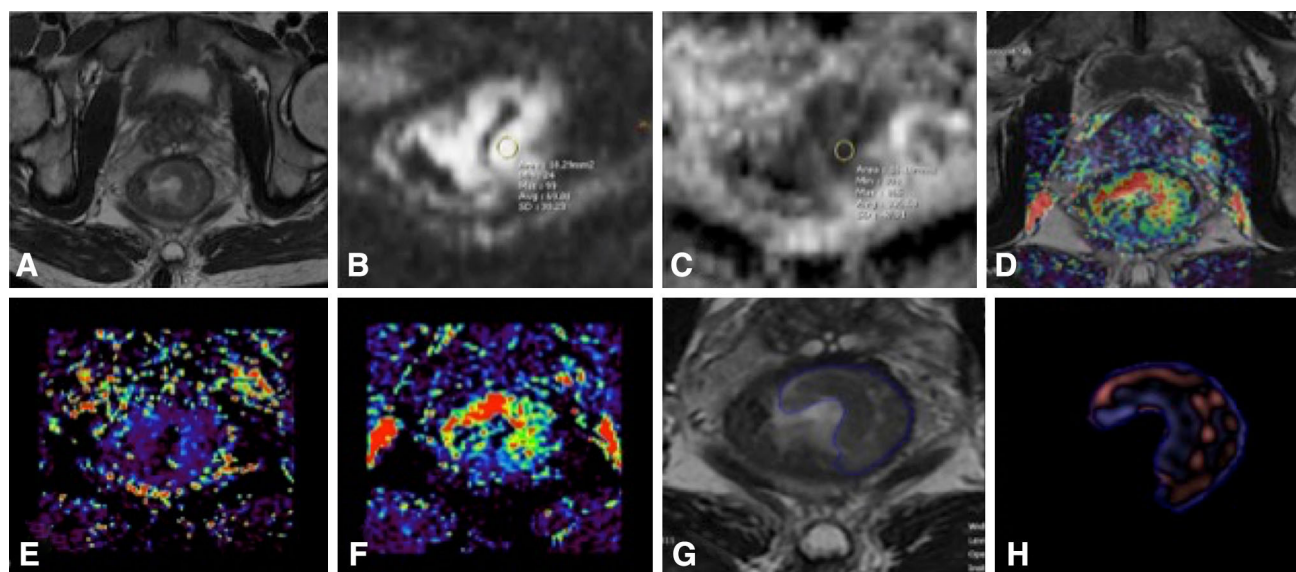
Multiparametric examination with DWI, pMRI, and texture analysis of a rectal tumor before neoadjuvant treatment. T2-weighted images with the rectal tumor (A) and corresponding DWI (B) and ADC (C); pMRI analysis showing
